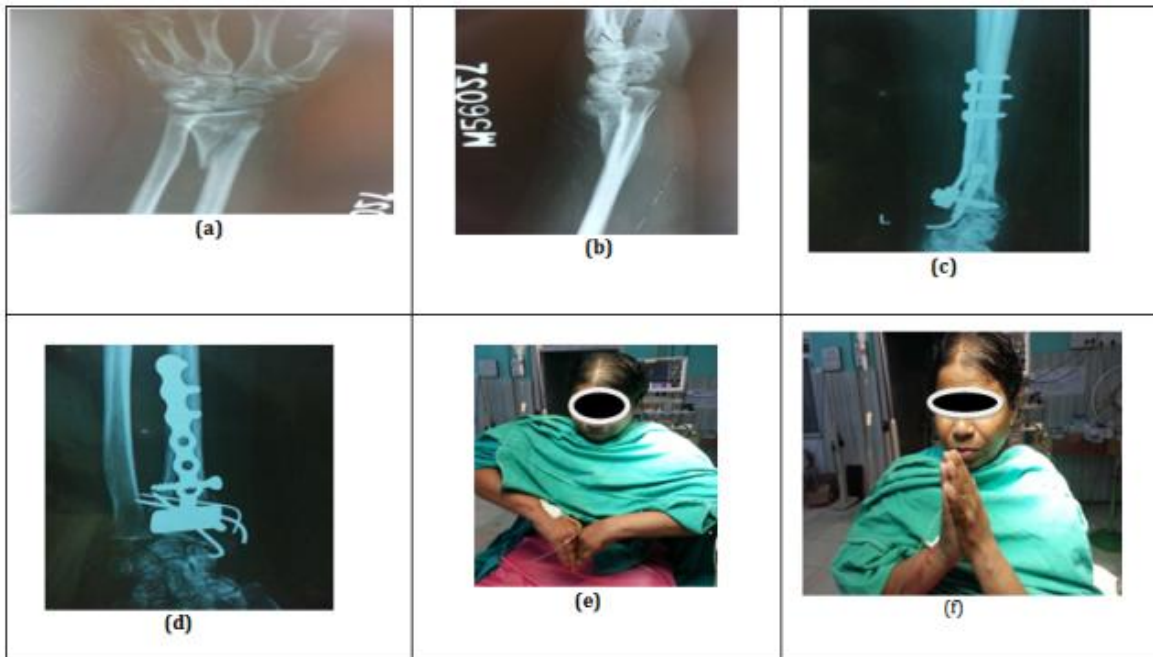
Patient with poor result: (a, b)-pre-op X-ray. (c, d)- final follow up X-ray. (e, f)- Clinical Photos
